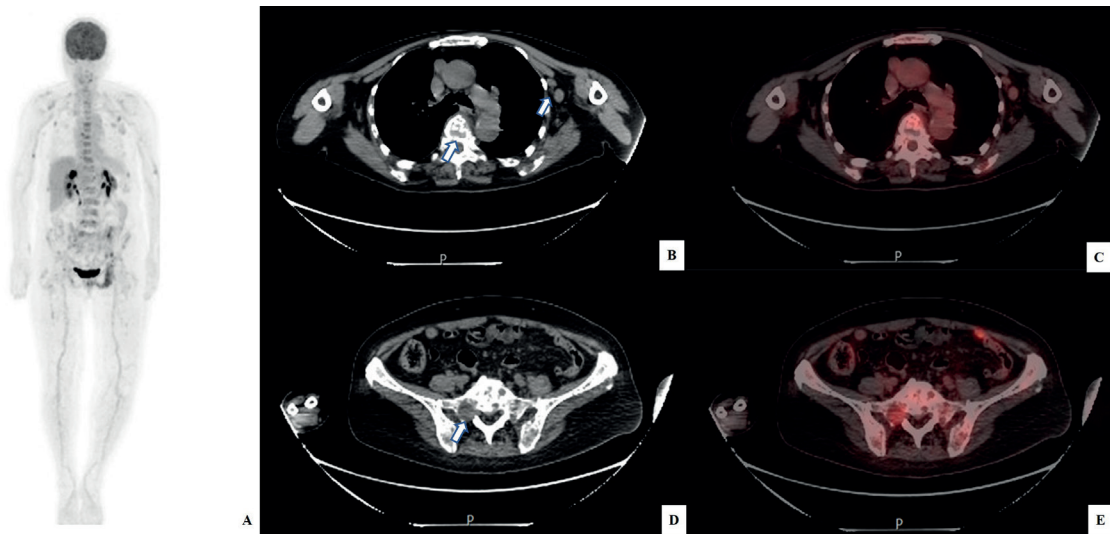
¹⁸F-FDG, PET/CT MIP image (A) revealed multiple FDG-avid metastatic tumor in the skeletal system (B, C); increased FDG uptake was observed in axillary lymph nodes (SUV_{max} 2.8); (D, E) increased FDG uptake was noticed in the right part of the sacrum (SUV_{max} 6.1).
